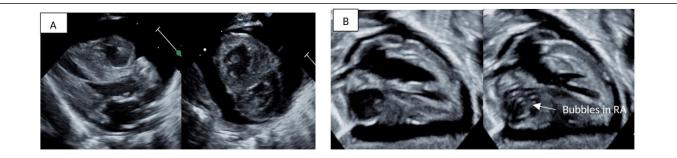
3A-Echocardiogram showing parasternal long axis view (left) and parasternal short axis view (right) with large circumferencial pericardial effusion at 16hours of life (DOL1). 3B: Echocardiogram showing bubbles in the RA during bubble study.
